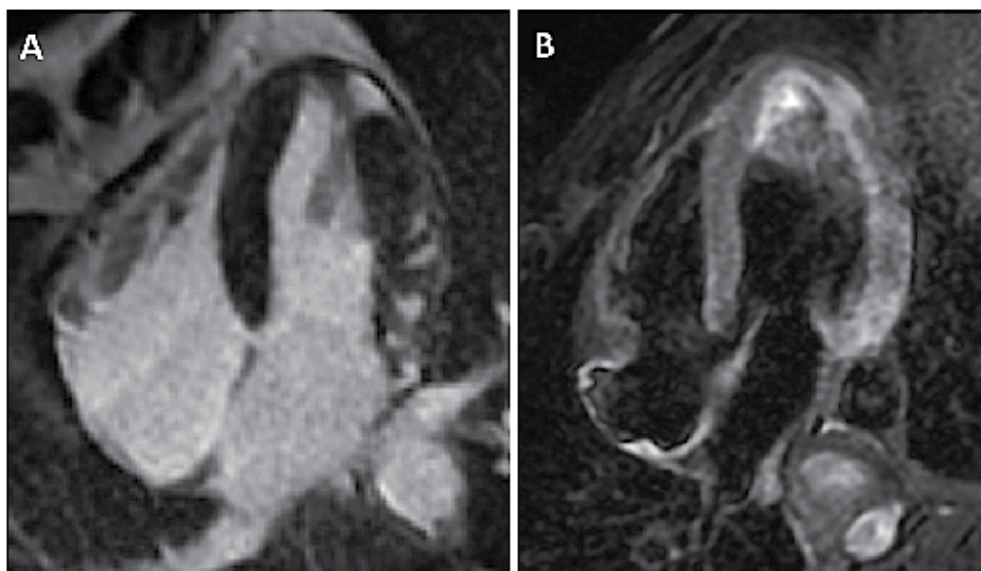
Diagnosis of myocarditis through CMR in a patient with sustained ventricular arrhythmias. Evidence of spotty areas of sub-epicardial and midwall late enhancement (non-ischemic pattern) in the lateral wall (A), associated with areas of edema (high signal intensity on T2-weighted images) in the same location (B). The presence of both late enhancement and edema fulfils the criteria proposed by the consensus document.
